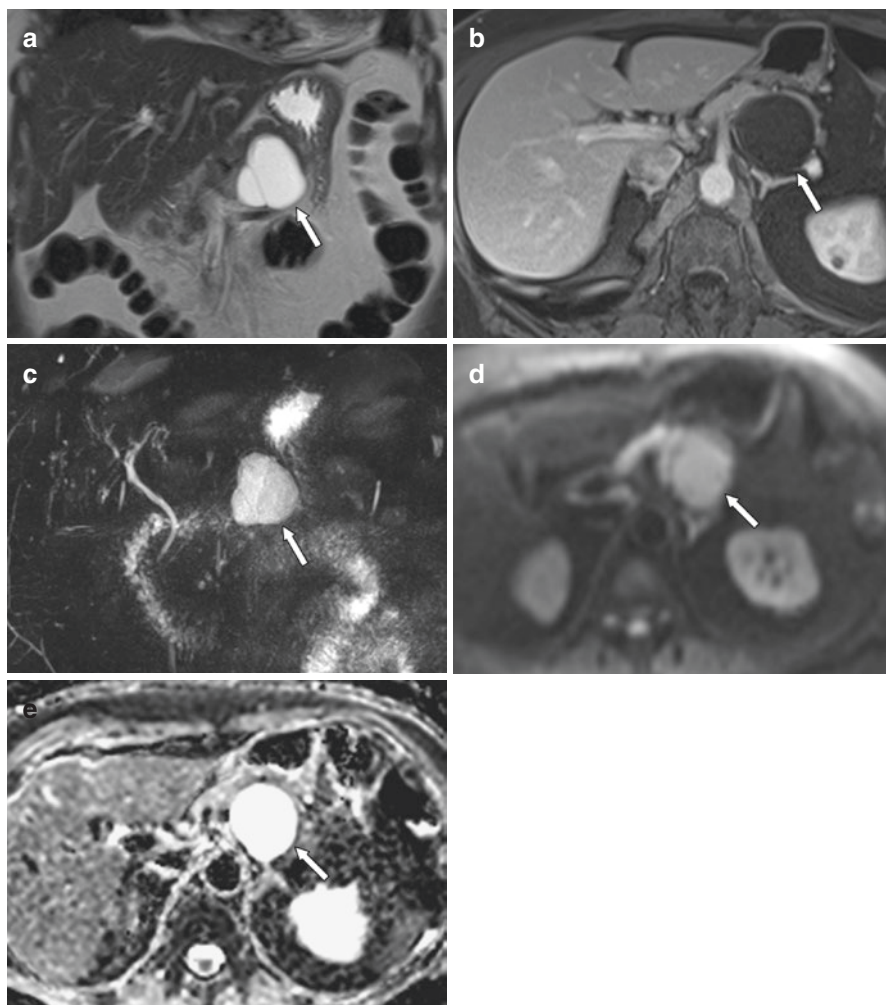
A 60-year-old male presenting for follow-up of a serous cystadenoma. (a, b) Coronal T2-weighted (a) and axial T1 post contrast (b) MR images show a lobular T2 hyperintense mass in the pancreatic head (arrows) with internal septations and a stellate central scar. The septations enhance on the postcontrast images (b). (c, d) DWI and ADC images show no restricted diffusion
